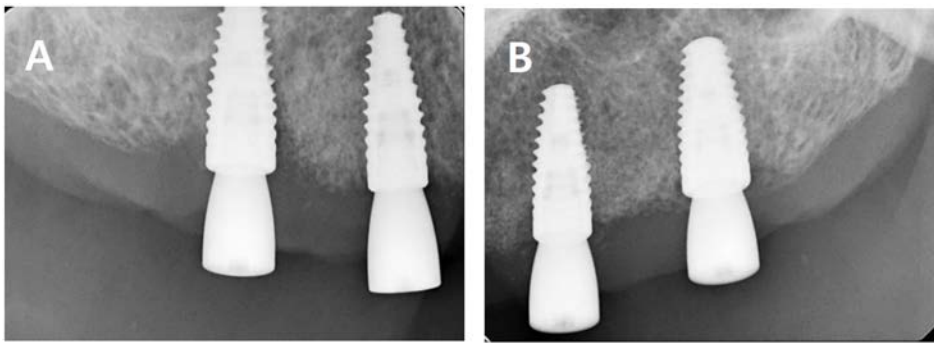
Periapical radiograph at 6 weeks later of implant surgery with peri-implant radiolucency on #15 implant. (A) #15, 13 implant. (B) #23, 25 implant.
